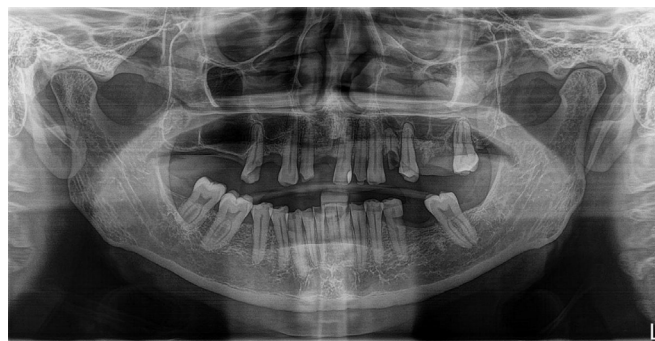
Panoramic radiography revealing an irregular radiopaque area within the soft tissue lesion.
